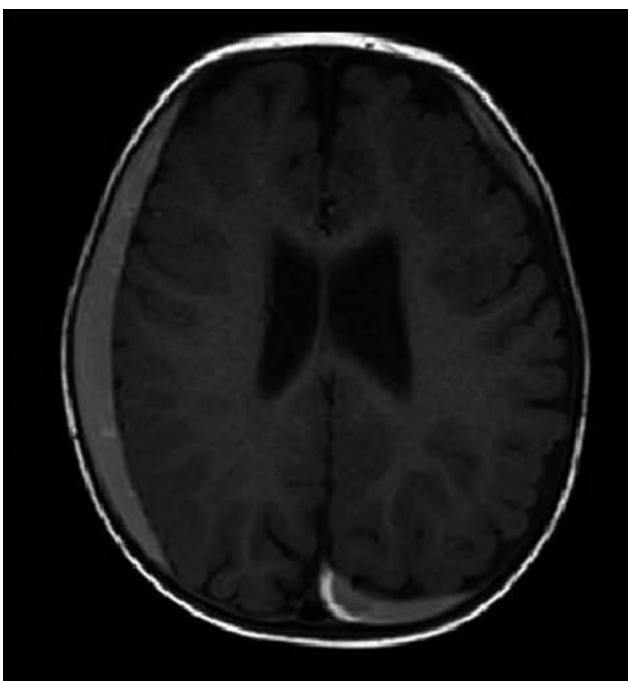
Brain MRI of case 1, axial and coronal T1-slices. Right frontoparietal and left parietooccipital subdural hematoma.
